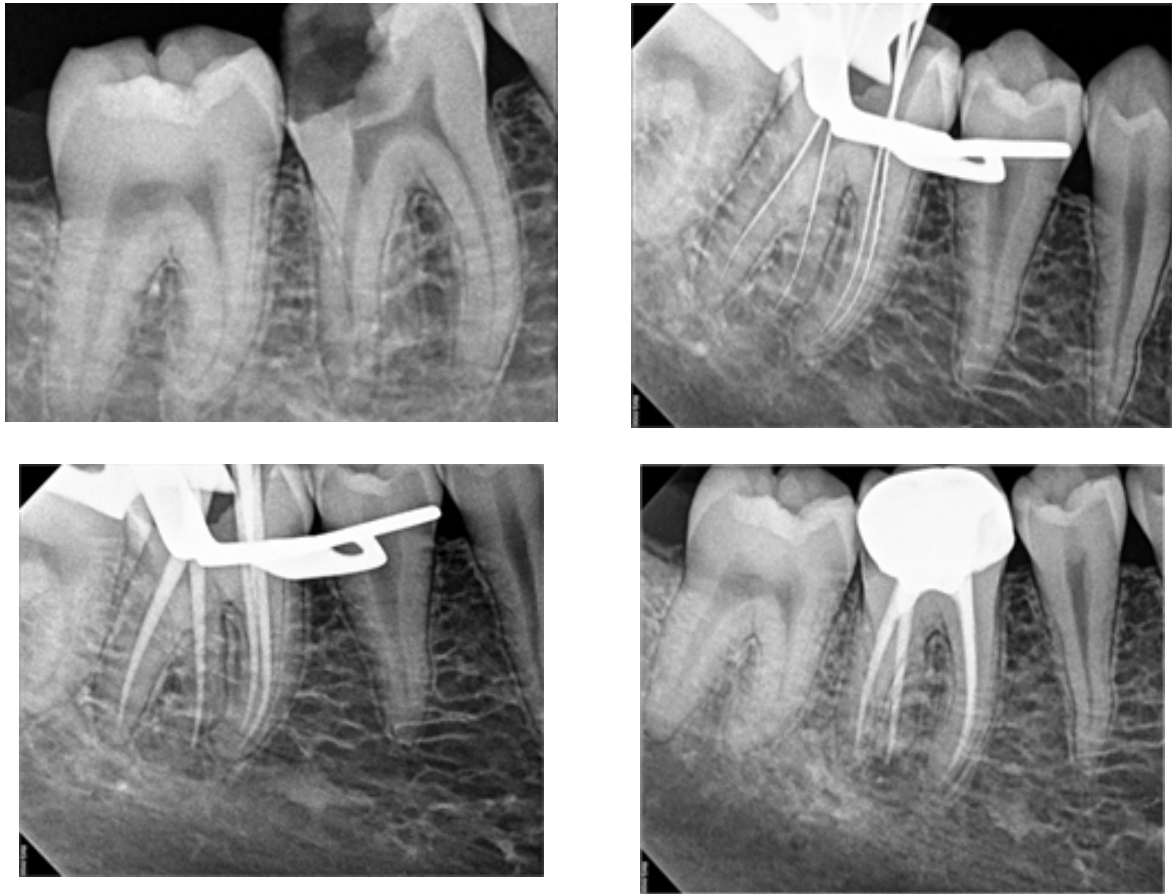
(a) Diagnostic Radiograph of 46 (b) Working length Radiograph of 46. (c) Master Cone Radiograph. (d) Post Obturation Radiograph
